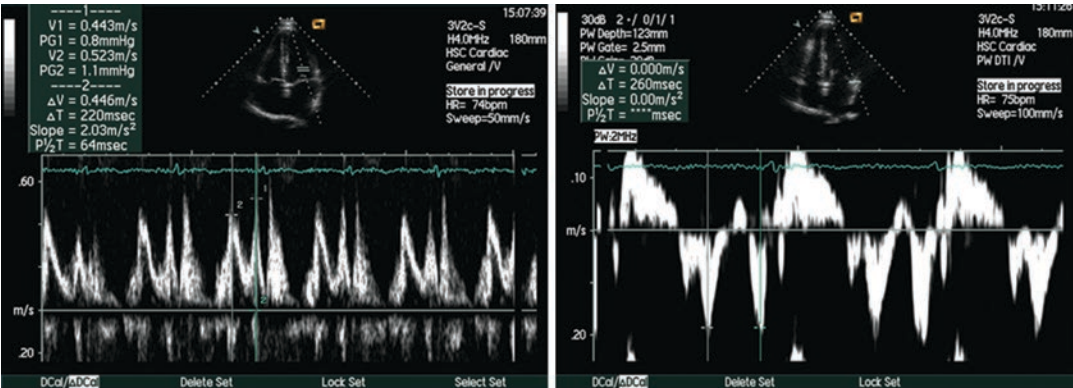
Doppler recordings showing (Left) blood velocity through the mitral valve and (Right) the velocity of the valve annulus
